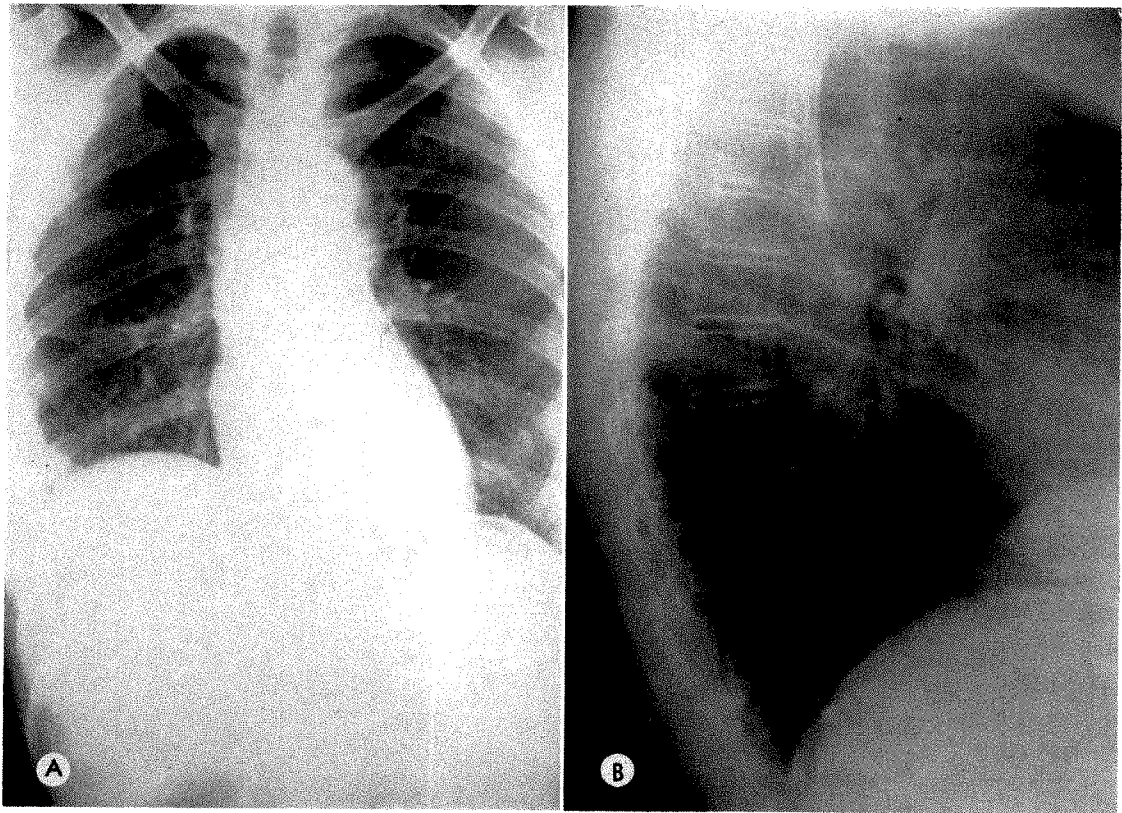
(A and B) Posteroanterior and lateral roentgenograms showing elevation of the right diaphragm and thickening of the oblique fissure.
